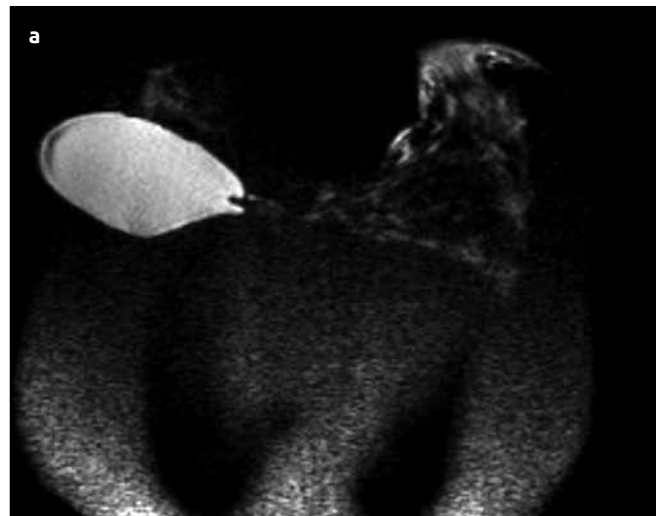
a, b. DWI (a) and ADC (b) showed that the left breast and pectoral muscle exhibited high SI due to the unrestricted diffusion
